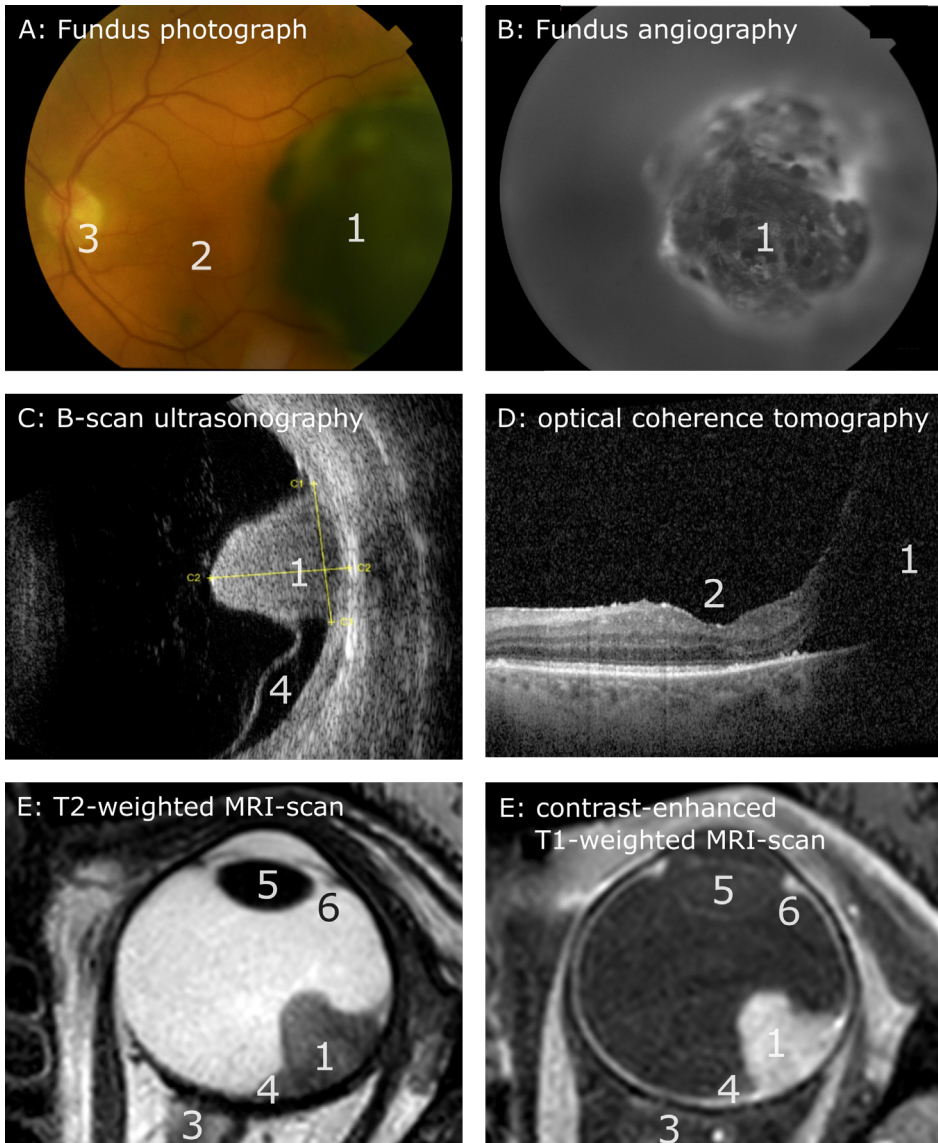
Several imaging modalities for a patient with a large mushroom-shaped uveal melanoma located temporally from the optic nerve of the left eye. (A) Fundus photograph, (B) fundus angiography, (C) B-scan ultrasound, (D) OCT-scan, (E) T2-weighted MRI-scan, (F) contrast-enhanced T1-weighted MRI-scan. Several structures are annotated: (1) tumour, (2) macula, (3) optic nerve, (4) retinal detachment, (5) lens and (6) ciliary body.
